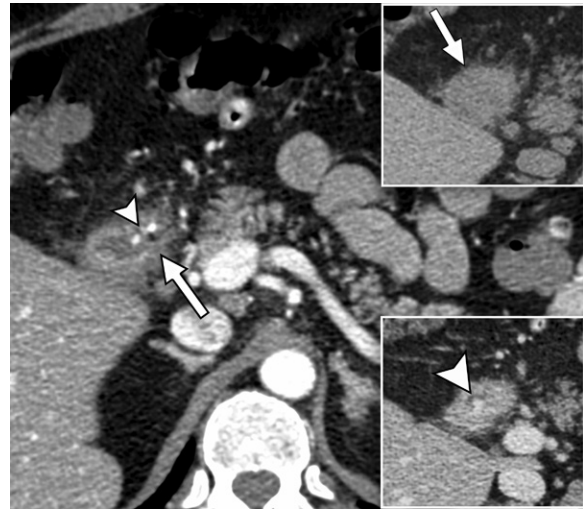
Duodenal ulcer with active bleeding in a 54-year-old man with anemia who presented with syncope and large-volume melena. Axial arterial phase (main image), noncontrast (top inset), and venous phase (bottom inset) CTA images show mild stranding adjacent to the proximal duodenum (arrow in top inset). On the arterial phase image there is discontinuous duodenal mucosal enhancement (arrow in main image), which is consistent with an ulcer crater, with associated duodenal wall thickening and adjacent stranding. There are foci of arterial enhancement (arrowhead in main image) that are not present on the noncontrast image and change in size, attenuation, and shape in the venous phase (arrowhead in bottom inset), which are consistent with active bleeding. After CT, the patient underwent angiography, which showed active hemorrhage from a gastroduodenal artery branch, and underwent gastroduodenal artery coil embolization. Subsequent endoscopy (not shown) demonstrated deeply cratered gastric and duodenal ulcers.
